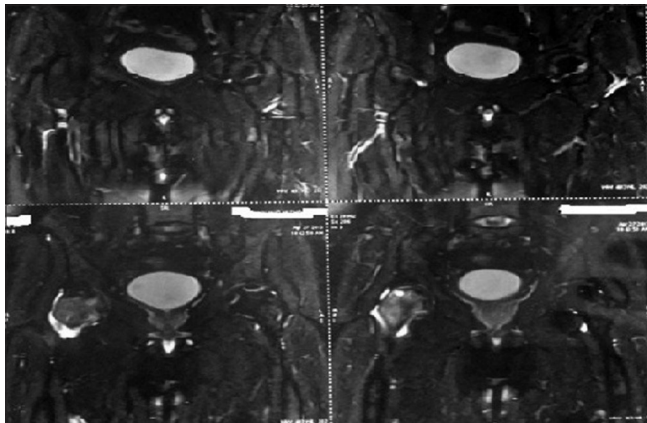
MRI of bilateral hip showing avascular necrosis of the femoral heads with the right side affected more than the left side
